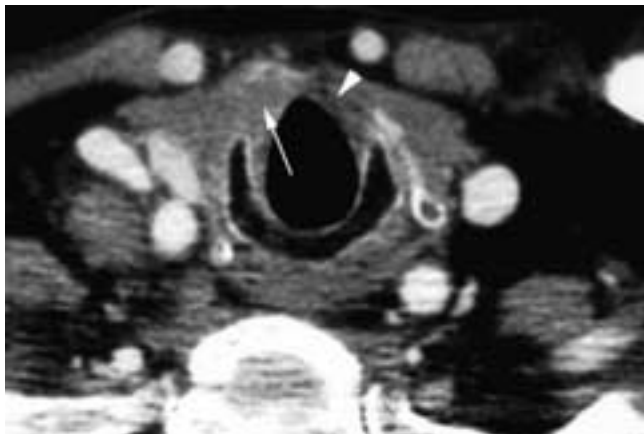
Tumor extension through the cricothyroid gap. Axial CT. The tumor originated at the true cord. Tumor extends anteriorly (*arrow*) between the cricoid and thyroid cartilages. Note the intact fat (*arrowhead*) on the opposite side related to the cricothyroid membrane.
